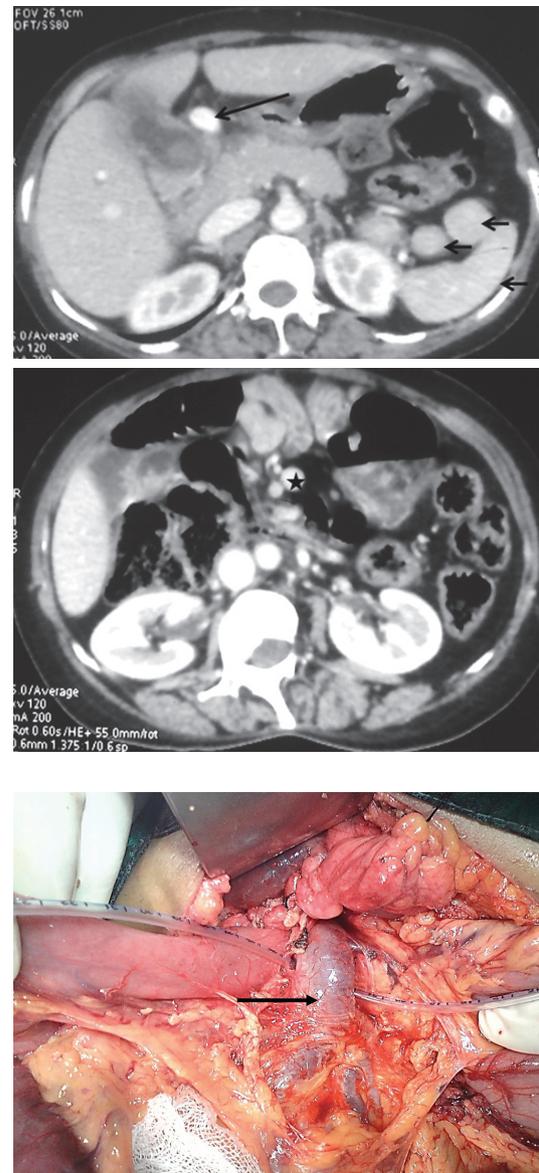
(A) Contrast-enhanced computed tomography showing the preduodenal vein (long black arrow) traversing the duodenum anteriorly and abnormally coursing towards fissure for ligamentum teres. Multiple spleens (short black arrows) are present in left hypochondrium (small arrows). Gallbladder wall is thickened and shows intraluminal hyperdense focus (calculus). Superior mesenteric vein is on the left side (star) and jejunal loops are not present in usual left hypochondrium consistent with malrotation of the gut. (B) Intraoperative photograph showing the portal vein (arrow) crossing the duodenum anteriorly
